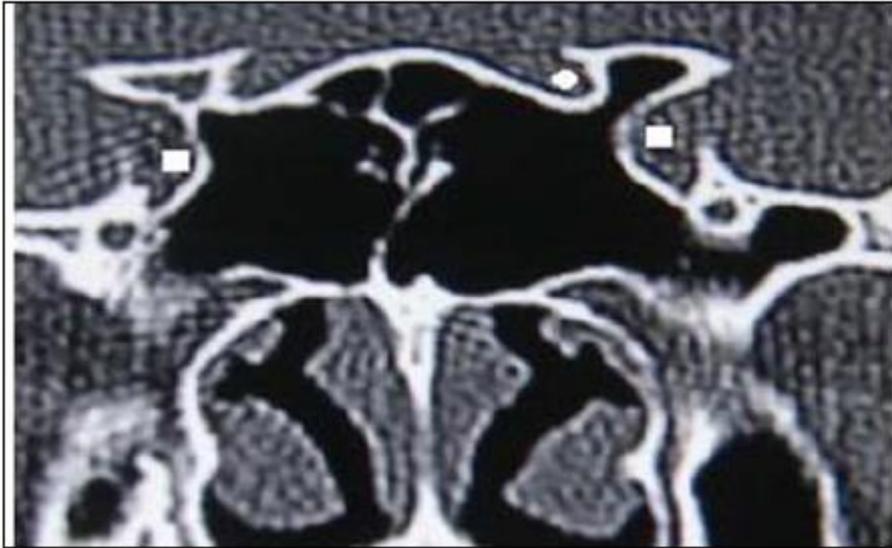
Coronal CT image showing protrusion of internal carotid arteries (squares), and protrusion of left optic nerve (circle)
